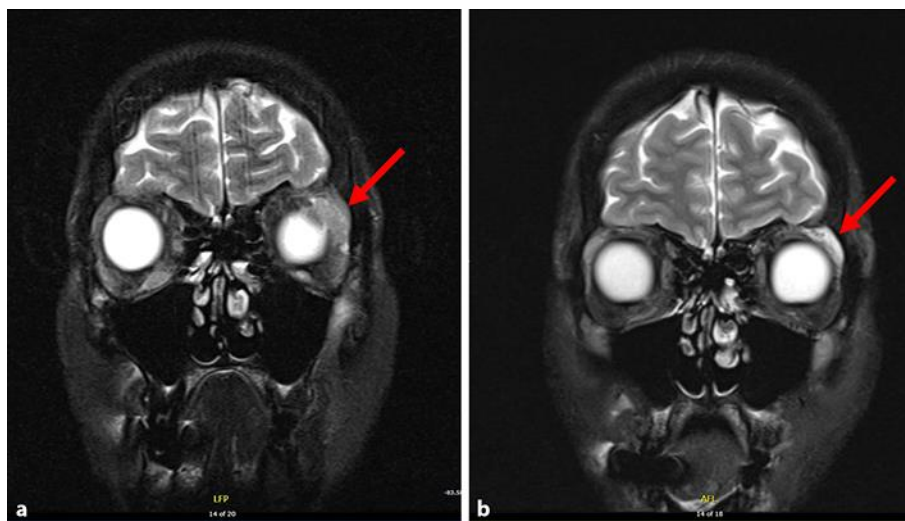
MRI image of orbital metastases. T2 MRI image of the orbits shows a metastatic lesion to the left lateral rectus muscle (arrow) which responded to treatment. a MRI orbits before treatment. b MRI orbits after receiving 3 months of treatment.
